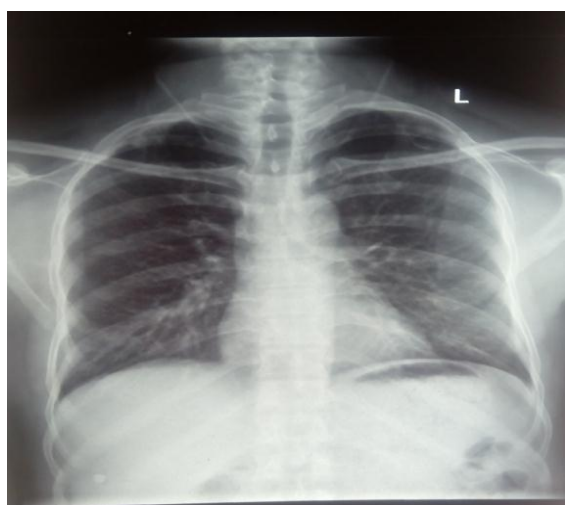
Chest radiography showing bilateral hilar lymphadenopathy with increased bronchovascular markings.
